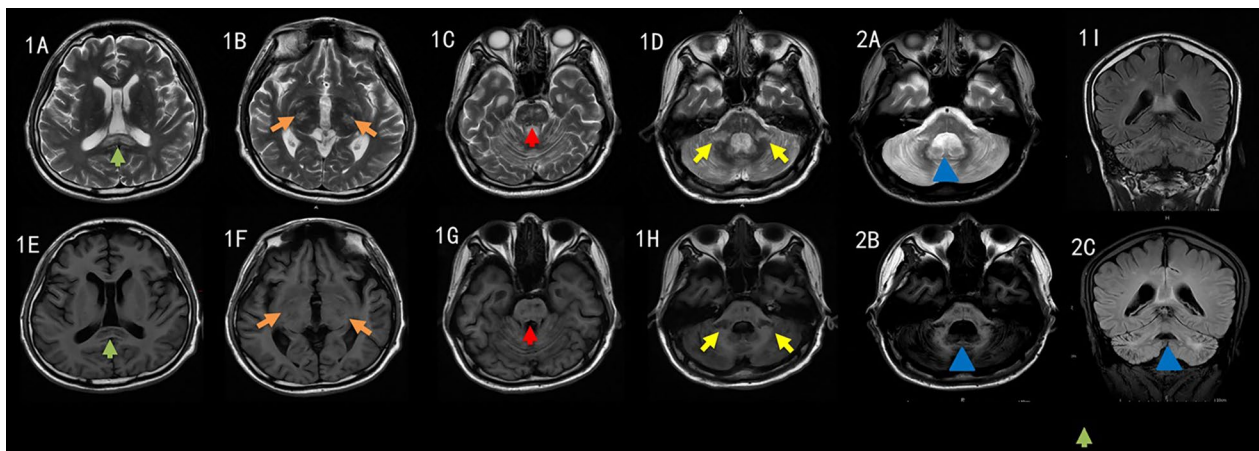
Changes in T1-weighted, T2-weighted and FLAIR imaging over time. Findings at 8 weeks (1): hyperintense and hypointense lesions on T1- and T2-weighted images, respectively, in the splenium of the corpus callosum (1A, 1E, green arrow), bilateral thalami (1B, 1F, orange arrows), brainstem (1C, 1G, red arrow), and brachium pontis (1D, 1H, yellow arrows). Slight cerebellar atrophy is seen in coronal magnetic resonance images (1I). Findings at the 6-month follow-up (2): follow-up imaging showed significant atrophy in the cerebellum and brachium pontis and an enlarged fourth ventricle (2A-2C, blue triangles)
